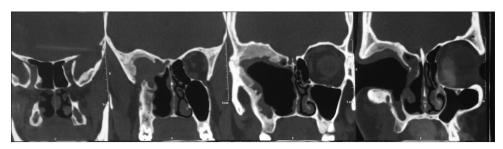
Computed tomography scan showing the defect
